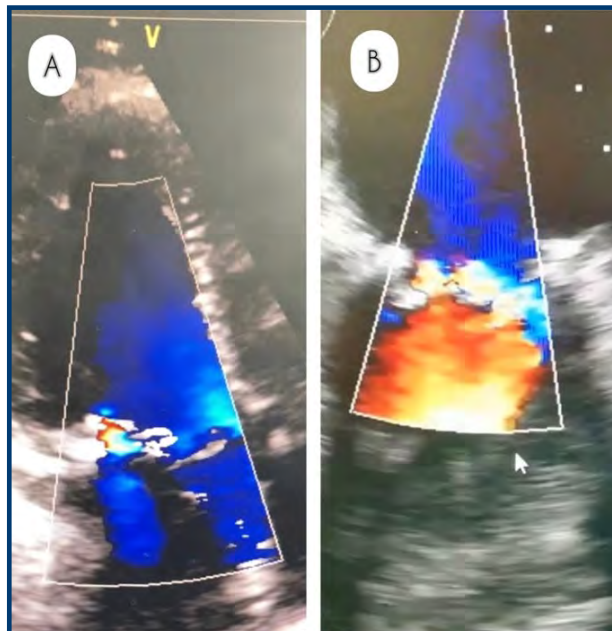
Post-surgical echocardiographic control. A. Apical transthoracic. B. Intraoperative transesophageal echocardiography.
